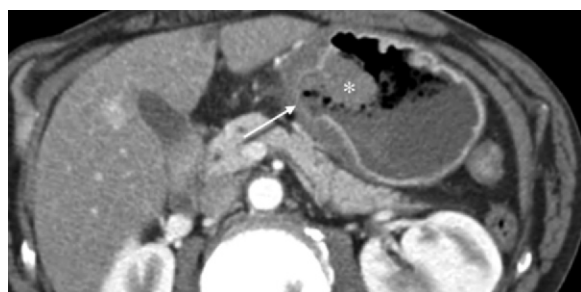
Hemorrhagic gastric ulcer. Axial CT image demonstrates a large gastric ulcer (arrow) with high-attenuation blood clot in the gastric body (*) and at the site of ulceration. Inflammatory changes are seen in the adjacent fat.
